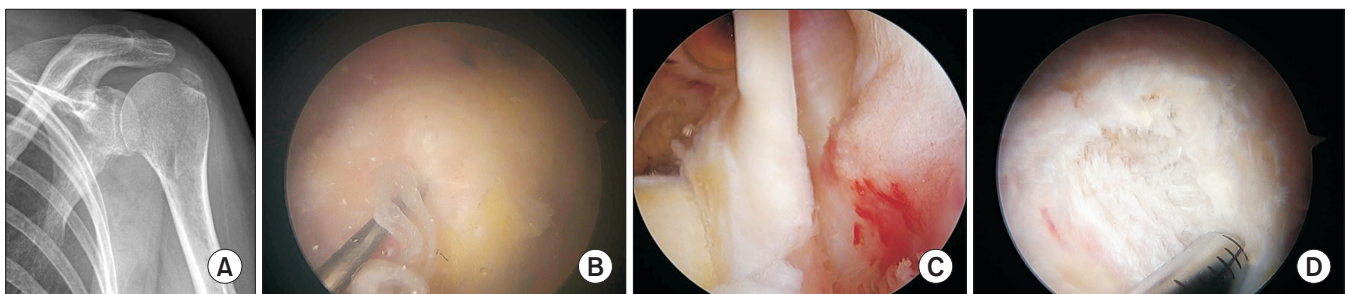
(A) Preoperative anteroposterior radiograph of a 62-year-old female patient (ID-5) suggests calcification on the greater tuberosity of the left humerus. Arthroscopic view from the posterior portal shows calcification of the infraspinatus over the greater tuberosity (B), and a 'cherry spot' lesion (C). (D) Poor tissue quality of the infraspinatus tendon may have resulted from having received three times of extracorporeal shockwave therapy and injections.
